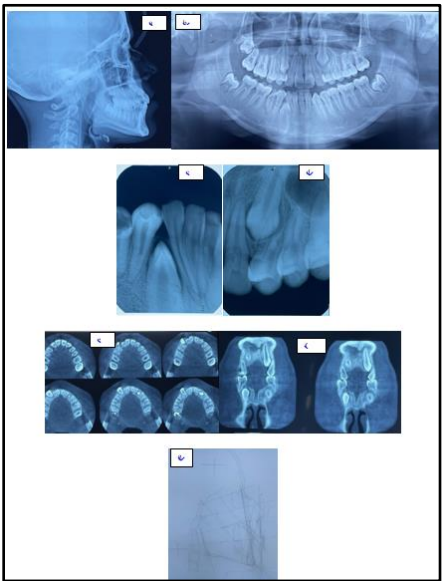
Pretreatment (a)Lateral cephalogram, (b)Panoramic radiograph, (c,d) IOPA wrt 23, 43 and (e,f) CBCT sections showing labial predisposition of 13 and mid-alveolar axial orientation of 23 in maxillary alveolar bone, cephalometric tracing (g).
